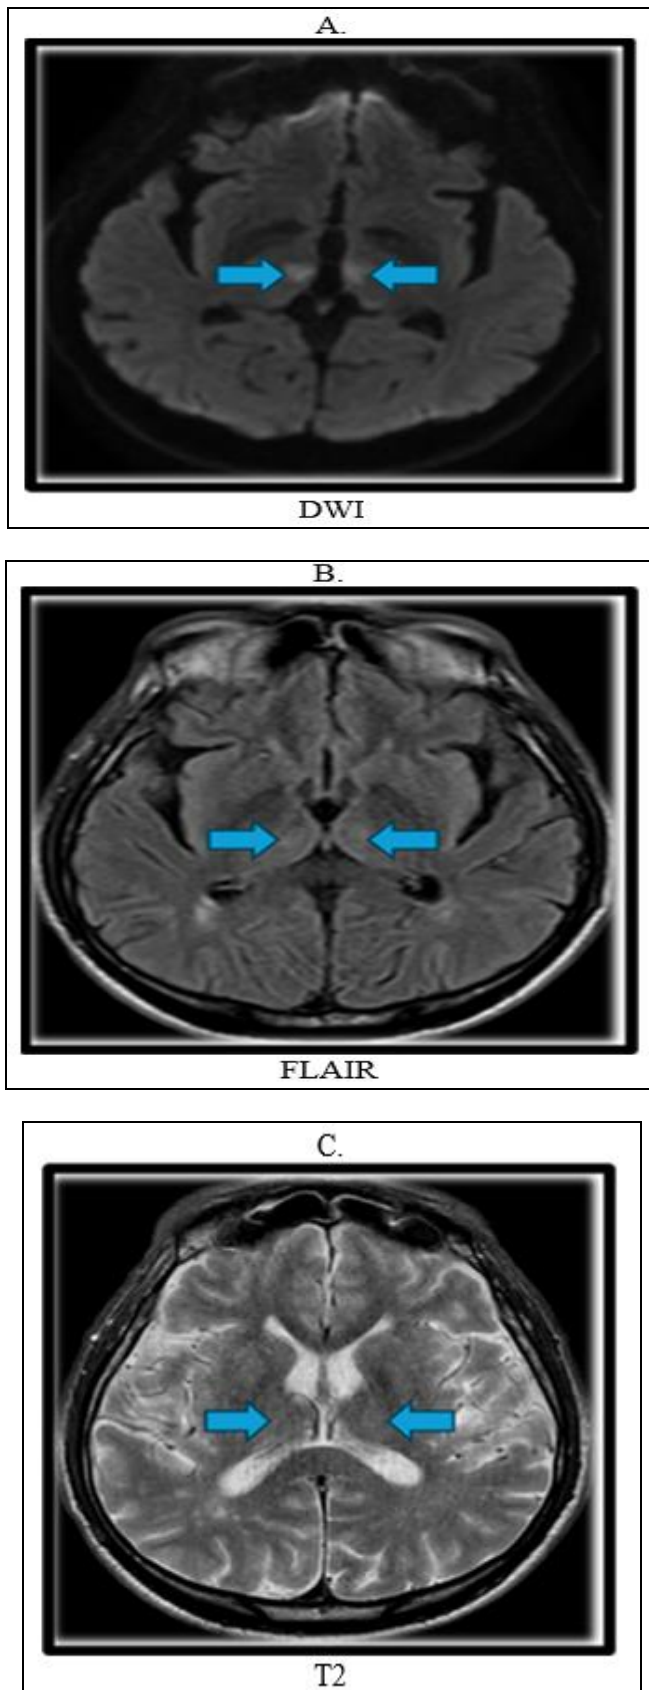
A. (DWI sequence) demonstrating bilateral paramedian hyperintensities at the thalamic level. B. (FLAIR) and C. (T2) showing incipient changes in the same regions, compatible with the onset of vasogenic edema. These findings suggest a late hyperacute ischemic event in the artery of Percheron territory.
